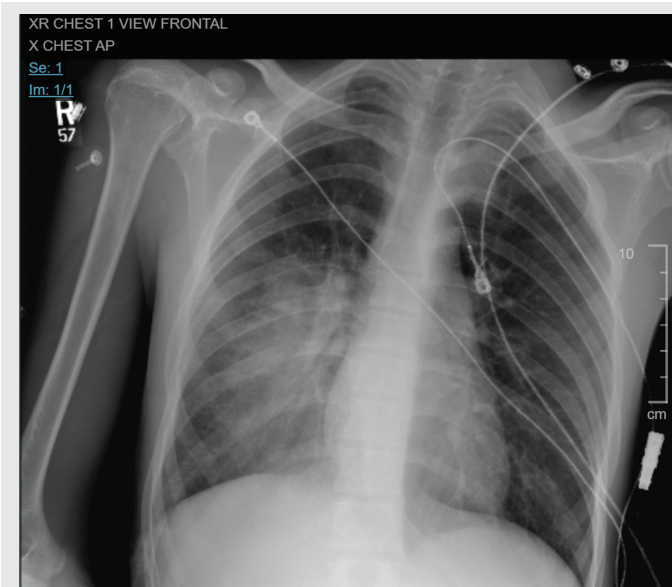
PA chest x-ray reveals a RLL infiltrate.
